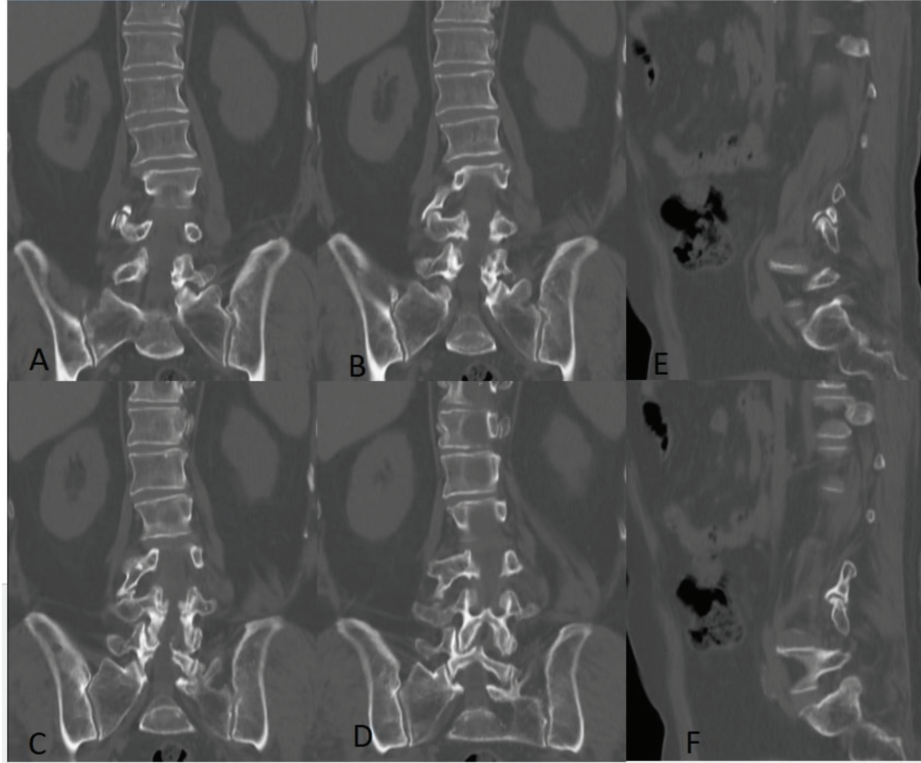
A-D; Coronal, E, and F; sagittal CT image shows “h” shaped osseous bridging and pseudoarthrosis between the right transverse processes of the L3, and L4 vertebrae, pseudoarthrosis
